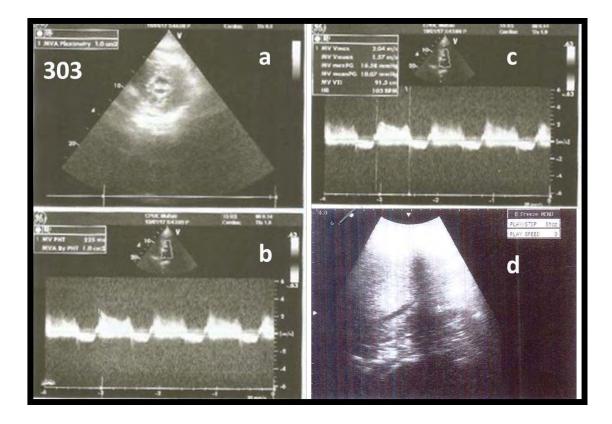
Echocardiography of subject 303 (a-c) depicting cardiac defects and ultrasonography of liver depicting liver echotexture parenchyma echogenicity (d).
